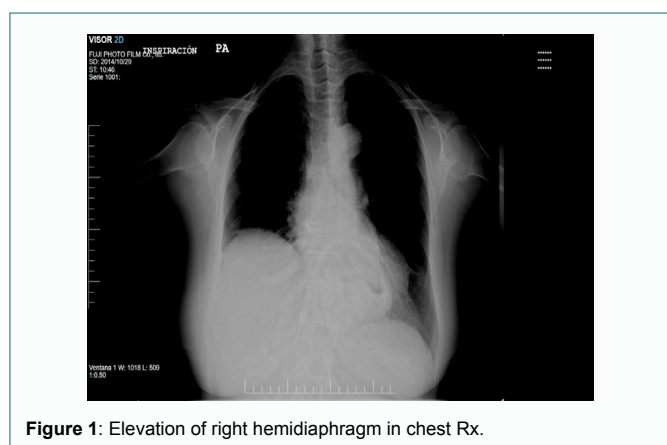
shows the chest radiography of one of the patients, which showed an elevated right hemidiaphragm.
